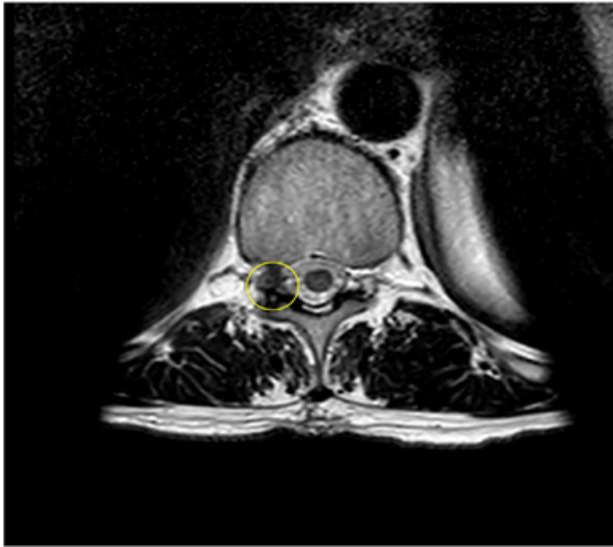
MRI T2 imaging of the mass.
